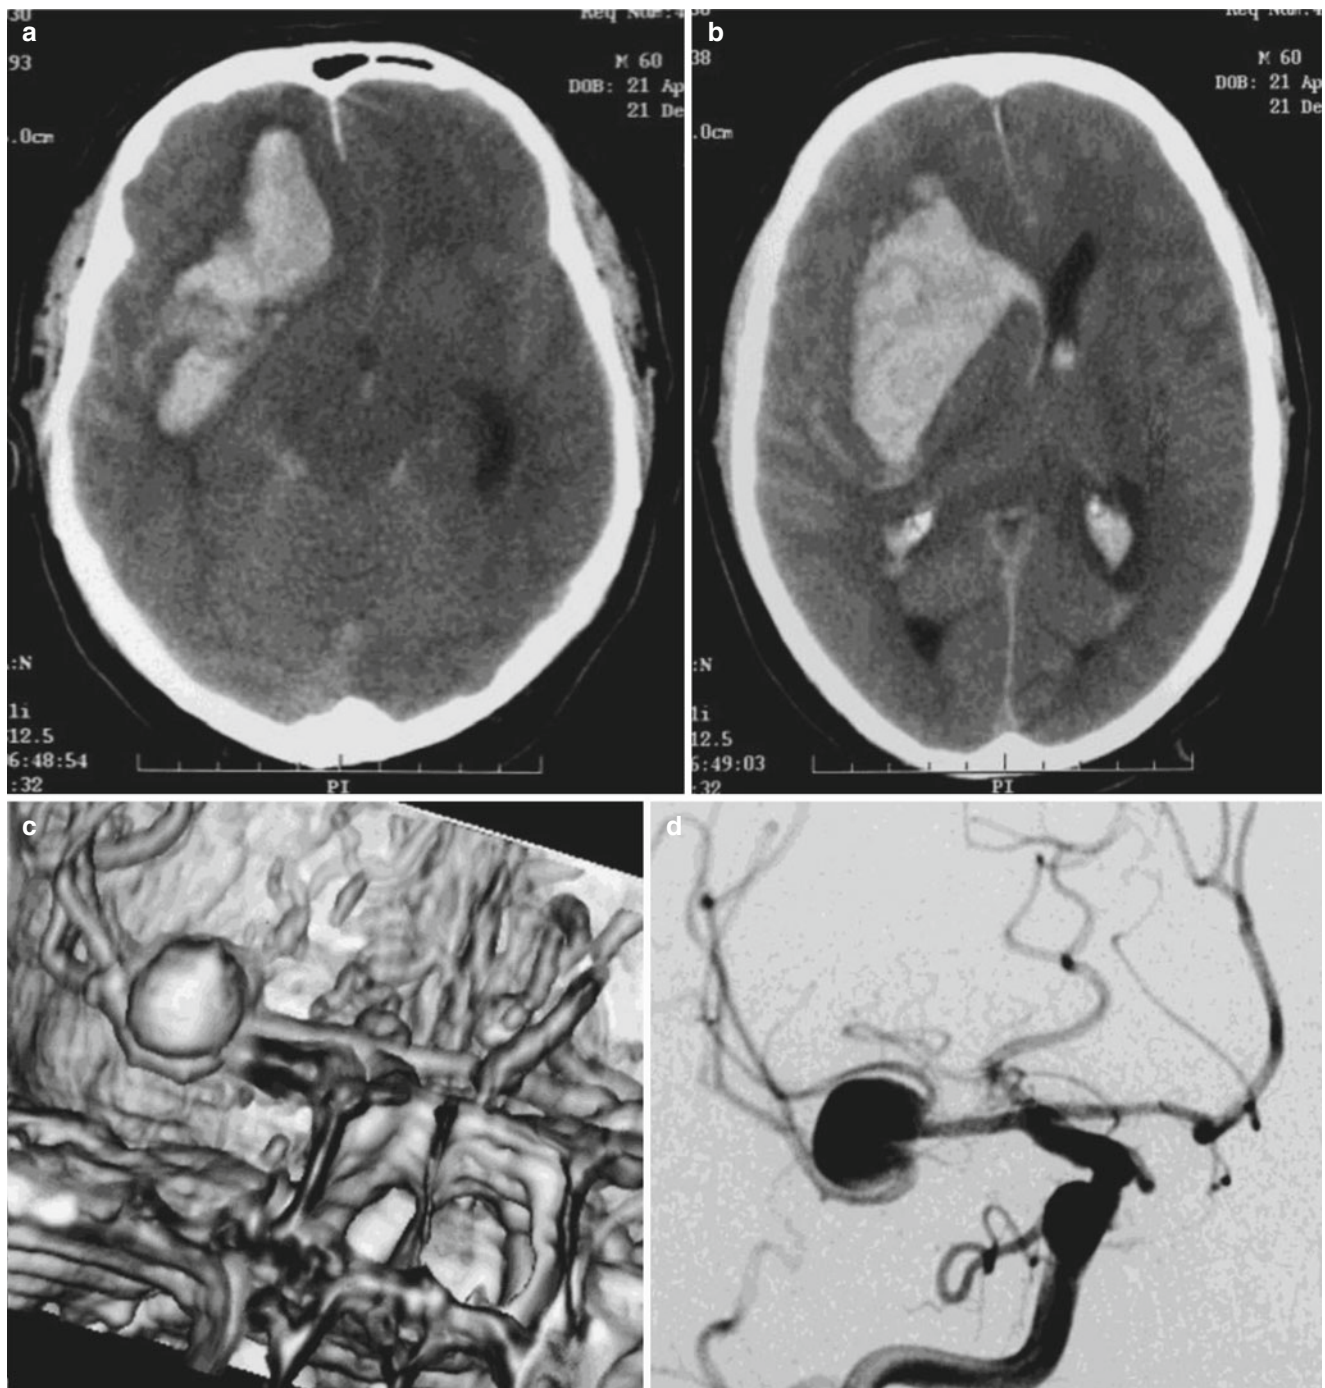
Sixty-year-old man presenting with stupor and left hemiplegia (GCS 6): (a, b) preop. CT scan; (c, d) preop. angio CT and angiography (note aneurysm on arrow-shaped division of right middle cerebral artery); (e) early postop. CT scan, after simultaneous evacuation of hematoma and clip exclusion of aneurysm (through temporary clipping
